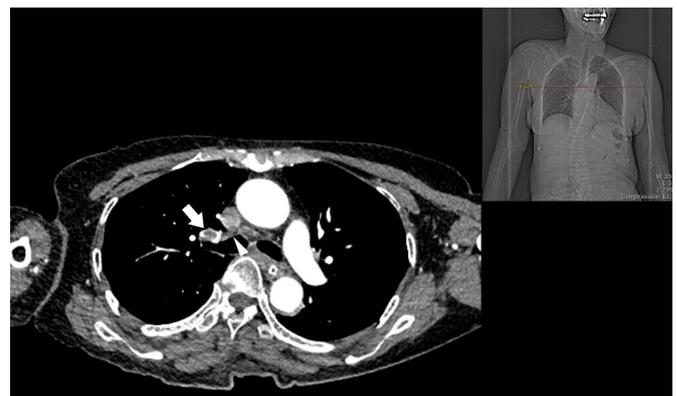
Computed tomography venography showed multiple thrombi in the pulmonary arteries (arrow) and superior vena cava (arrowhead).
